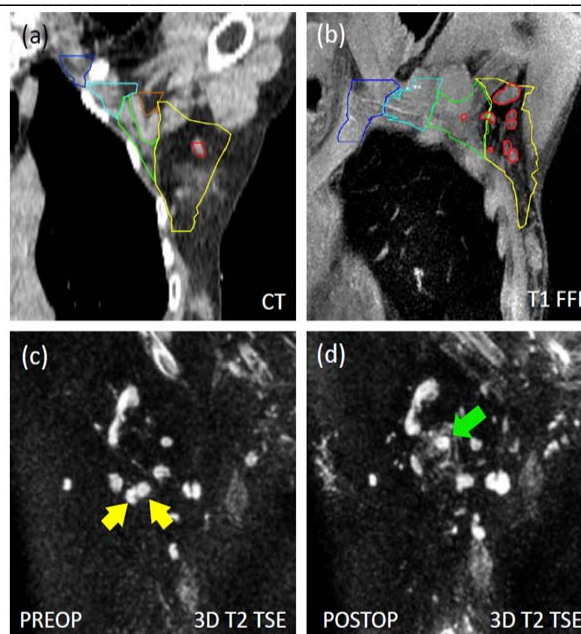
(a) Coronal CT scan with axillary levels contoured (axillary levels I-IV are yellow, green, sky blue, dark blue; inter-pectoral level is brown), according to ESTRO delineation guidelines. (b) Coronal T1-FFE MRI scan with in red individually delineated axillary LNs. (c) Preoperative coronal 3D T2 TSE scan where individual LNs are clearly visible (showing hyper-intense signal). The yellow arrows point to the two SNs which are excised during SNB. (d) The corresponding postoperative 3D T2 TSE; the SNs are now absent, while seroma due to the SNB is visible, as indicated by the green arrow.
